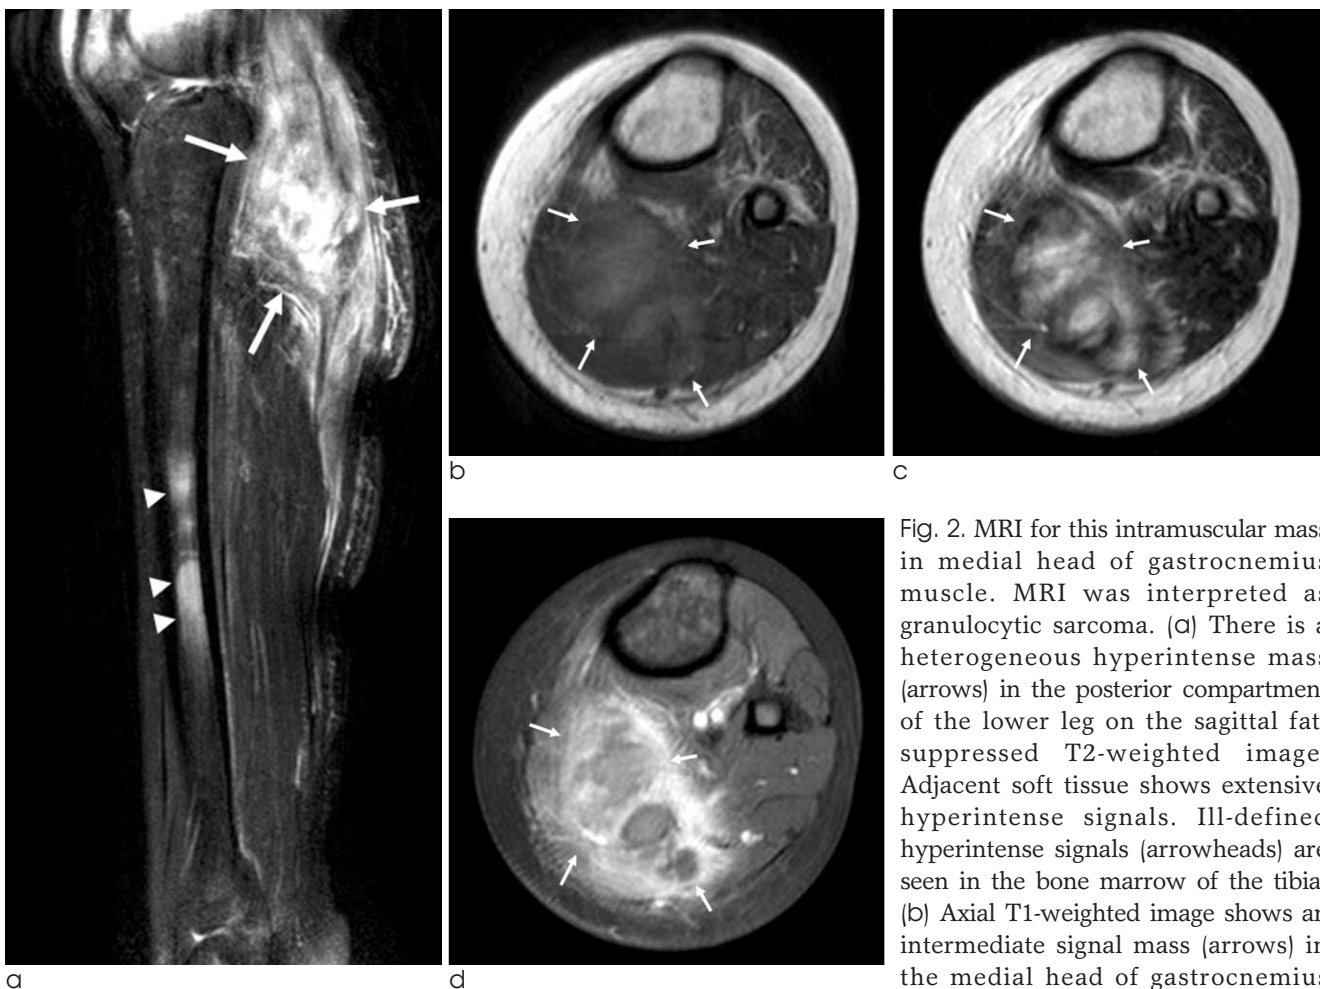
MRI for this intramuscular mass in medial head of gastrocnemius muscle. MRI was interpreted as granulocytic sarcoma. (a) There is a heterogeneous hyperintense mass (arrows) in the posterior compartment of the lower leg on the sagittal fat-suppressed T2-weighted image. Adjacent soft tissue shows extensive hyperintense signals. Ill-defined hyperintense signals (arrowheads) are seen in the bone marrow of the tibia. (b) Axial T1-weighted image shows an intermediate signal mass (arrows) in the medial head of gastrocnemius muscle. (c) The mass (arrows) is heterogeneously mildly hyperintense on axial T2-weighted image. Ill-defined, hyperintense signal is seen in the adjacent muscle. (d) On contrast-enhanced fat-suppressed T1-weighted image, it shows peripheral, thick, irregular contrast enhancement with central non-enhancing areas (arrows).
